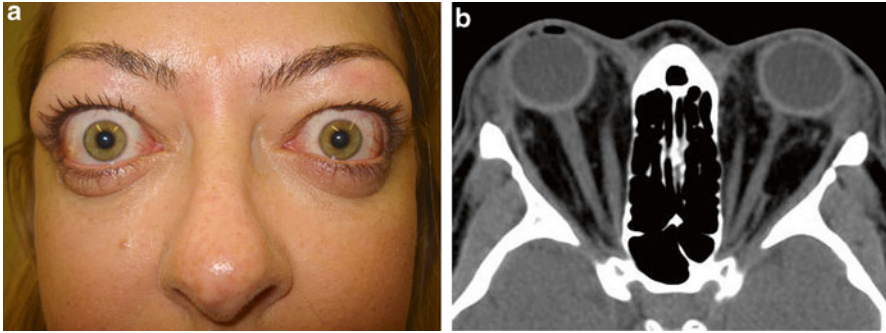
(a) A 32-year-old female with insidious onset of progressive bilateral proptosis and upper lid retraction and right lower lid retraction. (b) Axial CT Scan demonstrates proptotic globes with fat expansion and prolapse of enlarged lacrimal glands but no significant extraocular muscle involvement
